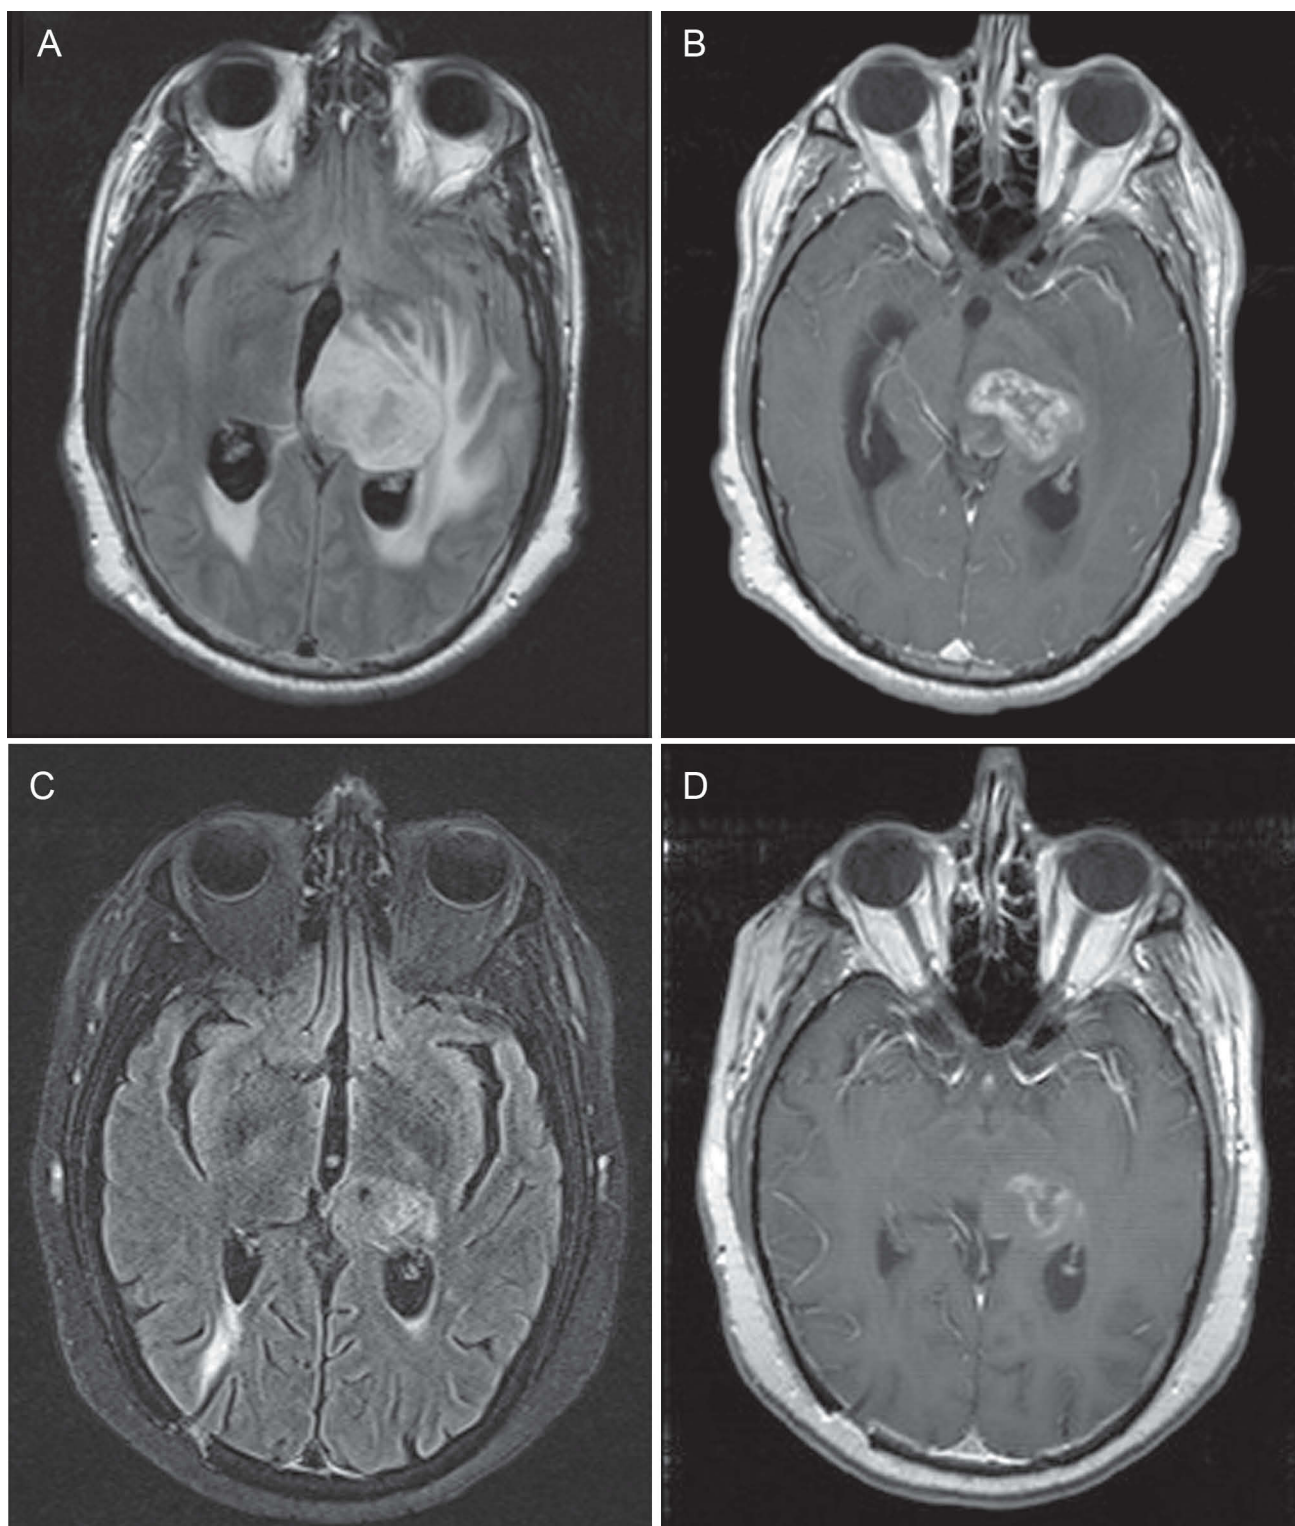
Magnetic resonance images of patient 4. Images A and B correspond to FLAIR and T1 sequences obtained after the patient developed a situation of major cognitive impairment on conclusion of the treatment with chemoradiation therapy. Images C and D correspond to the same sequences after one cycle of bevacizumab, and it is possible to see the almost complete resolution of the surrounding oedema.
